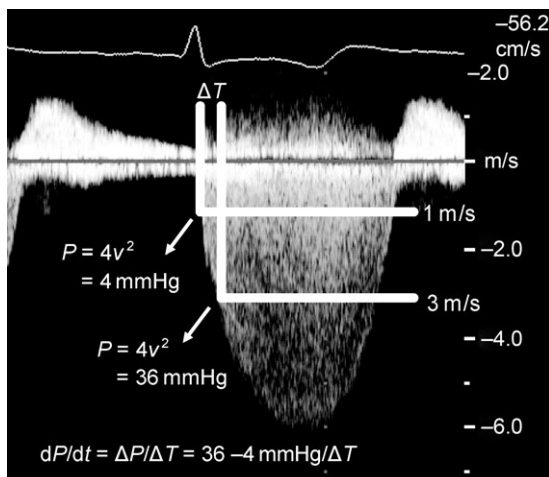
Doppler-derived dP/dt determined by measuring the time difference (ΔT) between two points on the continuous-wave mitral regurgitation spectral signal corresponding to 1 and 3 m/s. These points correspond to pressure gradients between the left ventricle and left atrium of 4 and 36 mmHg according to the modified Bernoulli equation ($\Delta P = 4v^2$). dP/dt is determined by this change in pressure (32 mmHg) divided by the time difference. P is the pressure, T the time, and v the velocity. Reproduced with permission from Barold *et al.*⁴⁸
